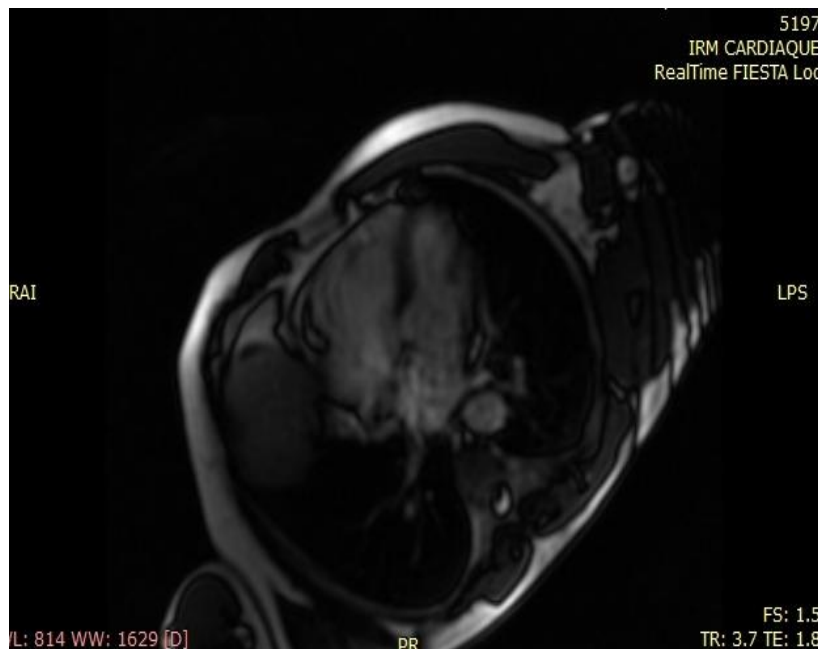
Cardiac 4 chamber MRI showing the RV dilatation with fatty infiltration.
